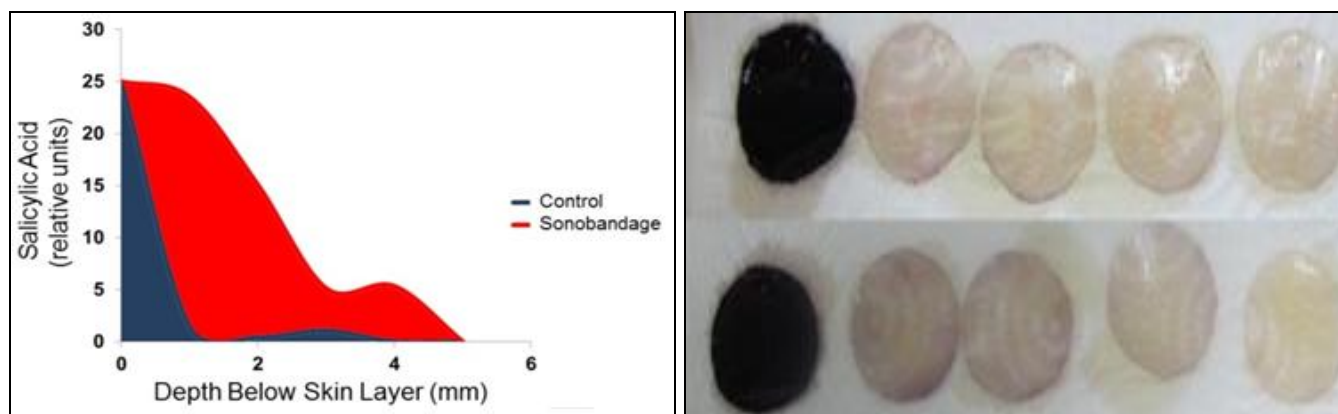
(A) SALICYLIC ACID MIGRATION THROUGH A SKIN MEMBRANE FROM A SOURCE (LEFT) INTO FOUR STACKED DISKS WITHOUT ULTRASOUND. (B) SALICYLIC MIGRATION THROUGH A SKIN-LIKE MEMBRANE WITH ULTRASOUND. EACH DISC ON THE RIGHT IS DARKER IN COLOR THAN THE ONE ABOVE IT, INDICATING MORE SALICYLIC ACID⁸
